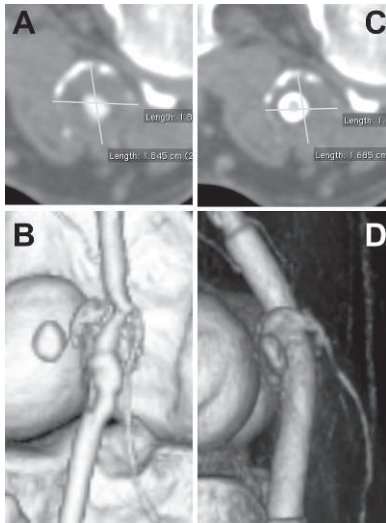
♦ (A) An axial CT and (B) 3D reconstruction show a type II A popliteal aneurysm (1.9×1.8 cm) with mural thrombus and side branches from the sac. (C,D) Images at the same levels at 1 year show shrinkage of the treated lesion (1.7×1.7 cm), a patent CMFM, and patency of side branches arising from the sac.
